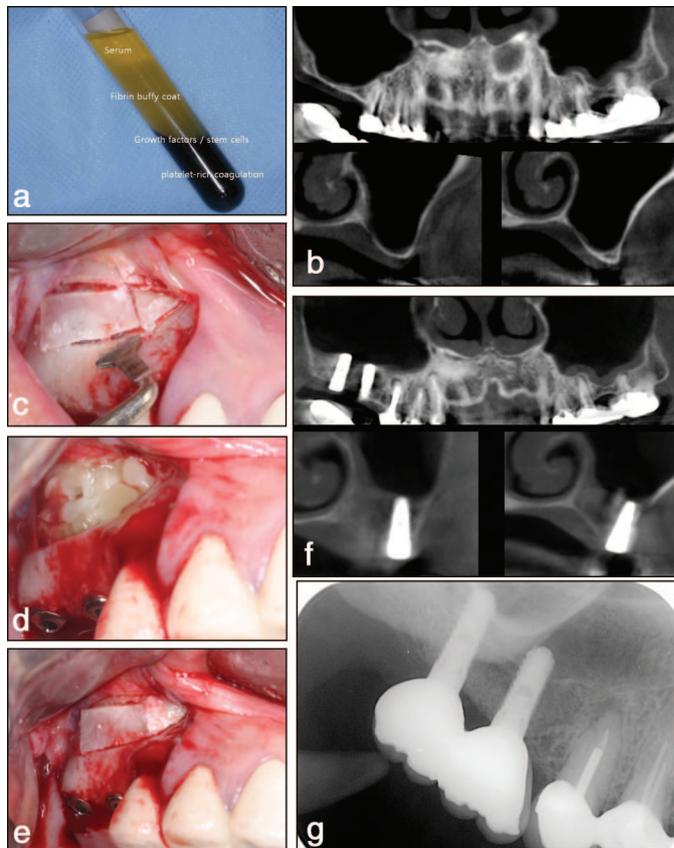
a, A fibrin-rich block with concentrated growth factors made by a specific centrifugation (Medifuge, Silfradent srl). The second and third layers were utilized for sinus augmentation. b, Cone-beam computed tomogram showing 1 to 2 mm bone height at the right maxillary second (left) and first molar (right), respectively (from patient number 50). c, The piezoelectric saw, connected to piezoelectric device (Surgybone, Silfradent srl), was used to create the replaceable lateral window of maxillary sinus in all cases. d, After careful elevation of the sinus membrane, 4 pieces of fibrin-rich block were inserted into the new compartment between the elevated membrane and the sinus floor. Two tapered design implants (Dentis Implants; Dentis Inc.) were placed simultaneously after a 1-step down osteotomy. The initial stability was good. e, The bony window was repositioned with stability to seal the window. f, Cone-beam computed tomographic scans revealed new bone consolidation along the implant body at the right maxillary second (left) and the first molar (right), respectively, after 18 weeks healing. Implants were uncovered at this stage. g, Radiogram after 5 months loading. Note the newly formed bone in the sinus.
